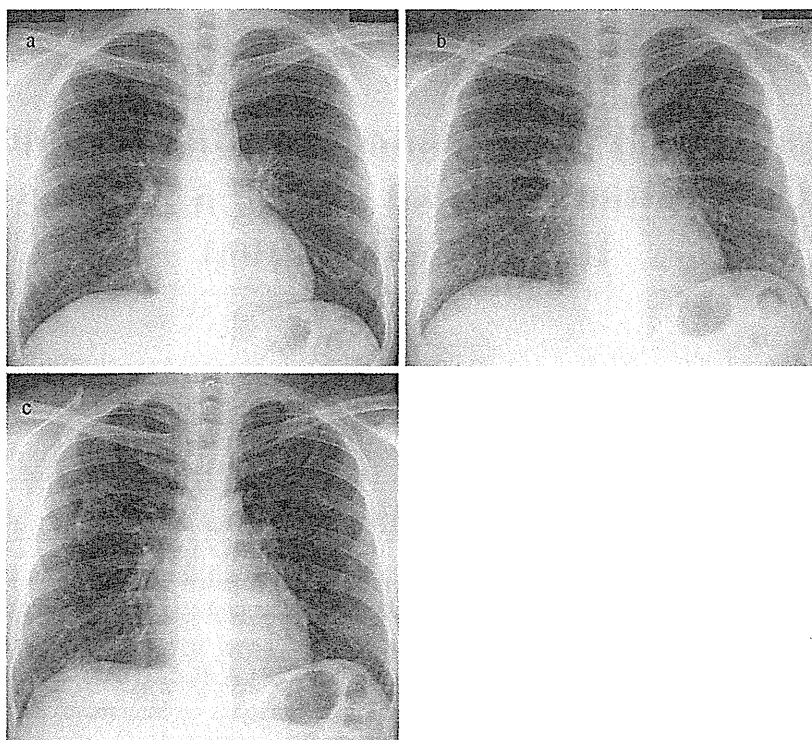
Chest radiographs taken in 2005 (a), 2007 (b) and on admission in 2008 (c) (these chest radiographs were taken under different conditions). A chest radiograph taken on admission showed small, diffuse linear opacities in the lung fields bilaterally. The images showed almost normal findings in 2005. The abnormalities first appeared in 2007 and had become apparent in 2008.
